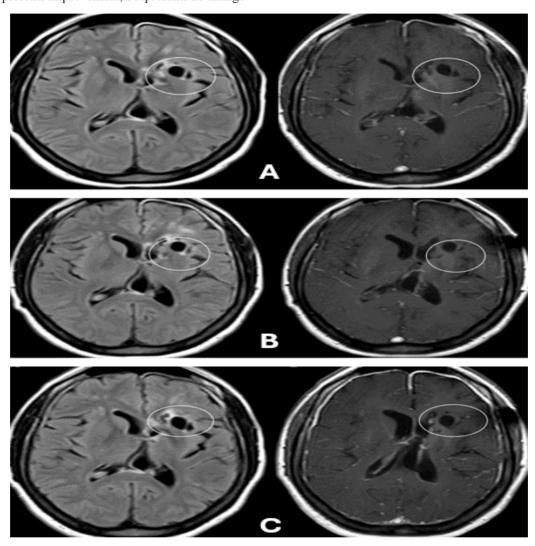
Follow-up studies for a known case of astrocytoma grade 2 with no evident tumor progression, (A) three-month follow-up scan and (B) six-month follow-up scan showed stationary appearance of the imaging findings with no new FLAIR or enhancing lesions keeping with BT-RADS 2, with still noted stationary appearance in the 12-months follow up scan (C).
